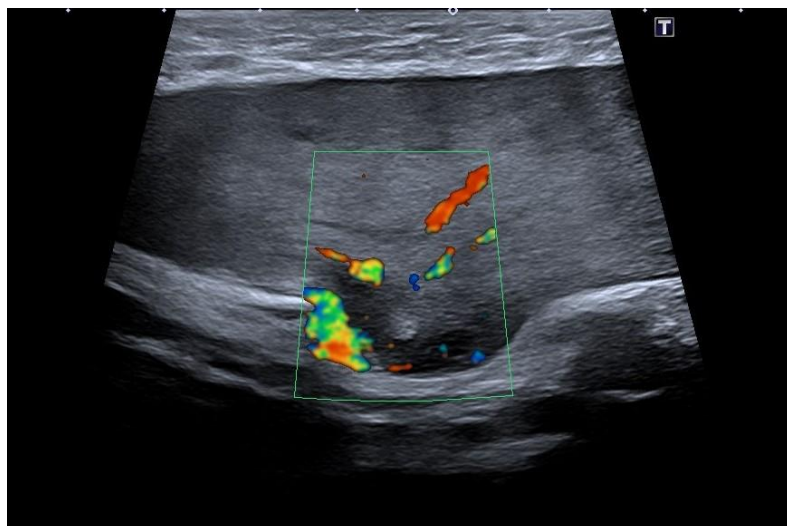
Well-defined hypoechoic lesion, moderately vascularized on Doppler mode - imaged with a linear probe
